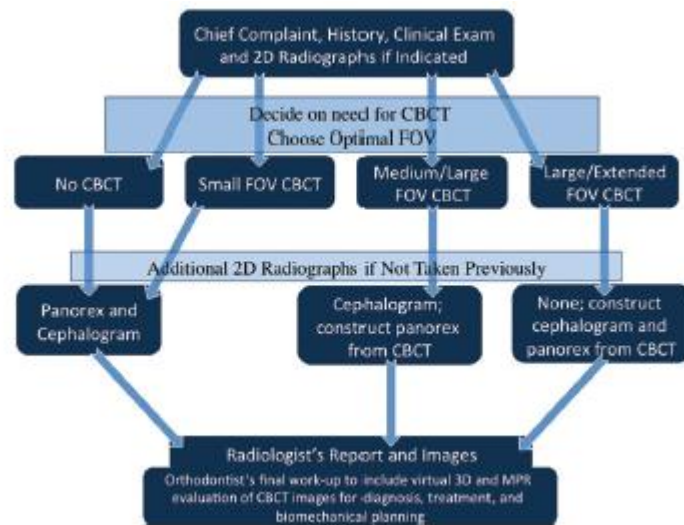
Efficacy of using CBCT in Orthodontics (Cone Beam Computed Tomography in Orthodontics, Sunil K, 2014)
